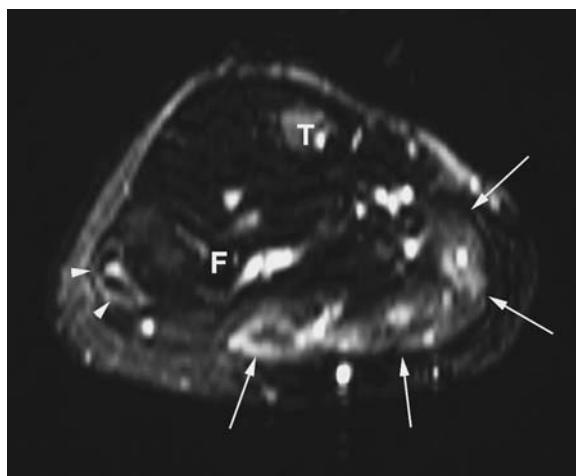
Running athlete with chronic exertional right leg pain, clinically related to soleus. Axial T2-weighted fat suppressed MR image post exercise shows soleus edema (arrows). Note asymptomatic peroneus muscle edema (arrowheads)
